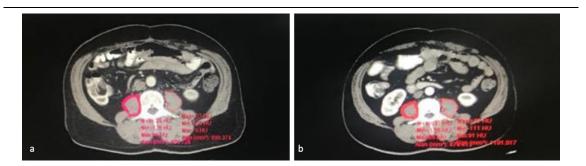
Evaluation of psoas muscle index in the same patient.a) CT image before neoadjuvant chemotherapyb) CT image after neoadjuvant chemotherapy (before surgery)
